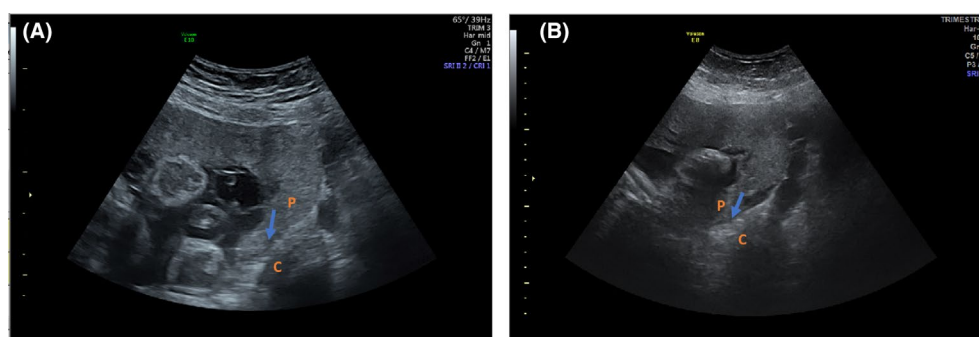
Abdominal ultrasound images showing a placenta previa covering the internal cervical os. C, cervix; P, placenta. (A) At 28 weeks of pregnancy and (B) at 33 weeks of pregnancy.
